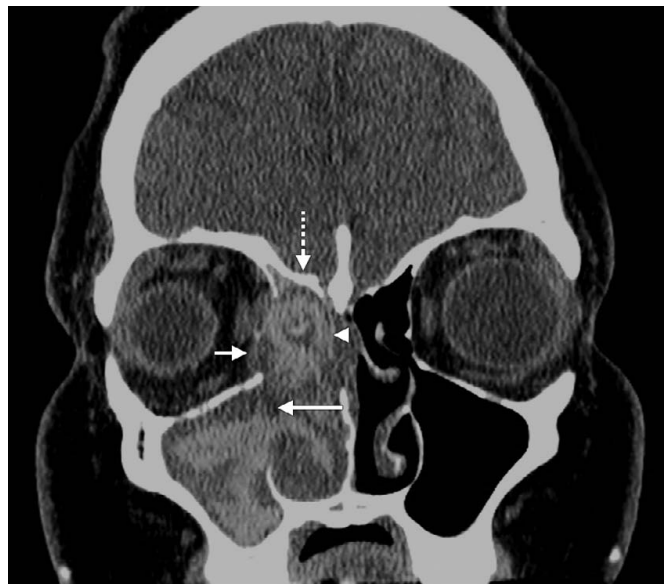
Invasive fungal sinusitis. Coronal computed tomography (CT) demonstrates fungal sinusitis with mixed density material widening the right osteomeatal unit (long arrow), extension into the nasal cavity, and invasion of the ethmoid sinus (arrow head) and right orbit (short arrow). Thickening of the right fovea ethmoidalis (dashed arrow) is due to chronic inflammation.
